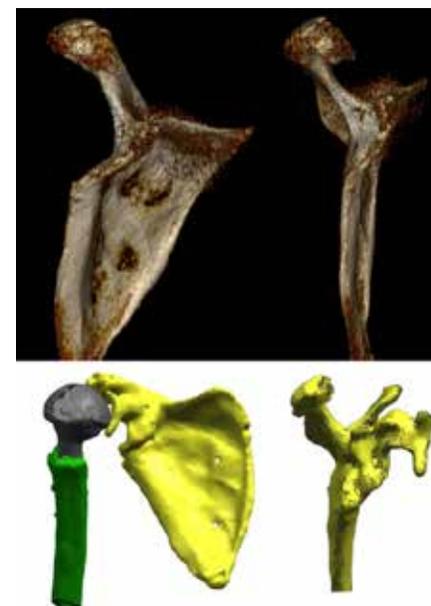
Preoperative 3D analysis of a dislocating CTA Hemiarthroplasty. Missing glenoid, chronic coracoid fracture and practically no possibility for a standard RSA or bone grafting.
